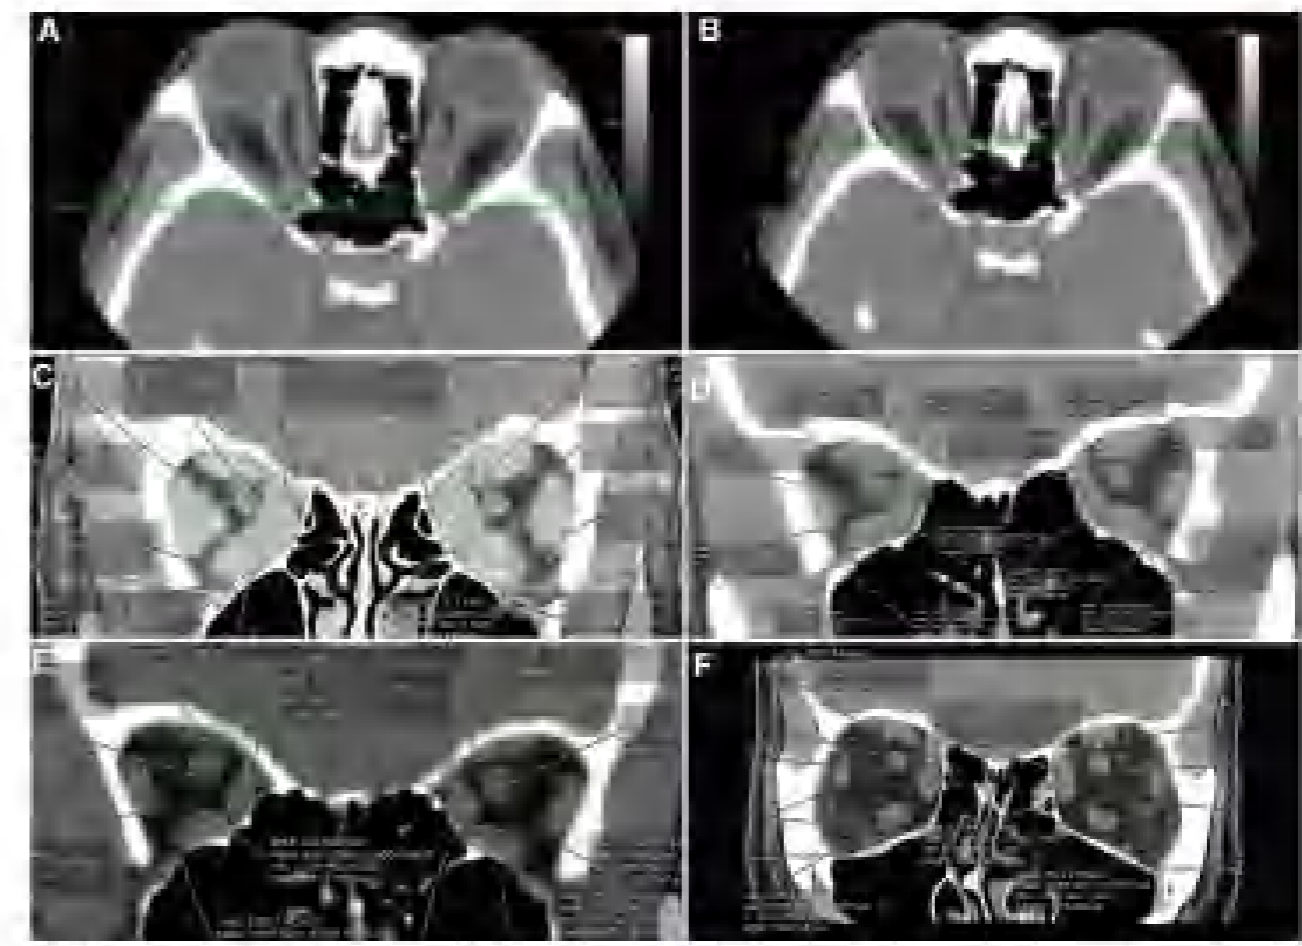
Correlative analysis. Axial and coronal CT orbitotomy images are introduced in the coronal plane. The anterior border of the superior orbital foramen (SOF) is identified as the initial reference point (A, horizontal green line). From a point 1.5 mm ± 2 mm anterior to the SOF to the next plane is identified (B, horizontal green line). In the corresponding coronal image, orbitotomy marks (ODM) and optic nerves are marked in various lateral orbit ratios (C) 25%, (D) 50%, (E) 75%, and (F) 100%. All measurements were done using Dicom Analyzing Software (GE Healthcare).
